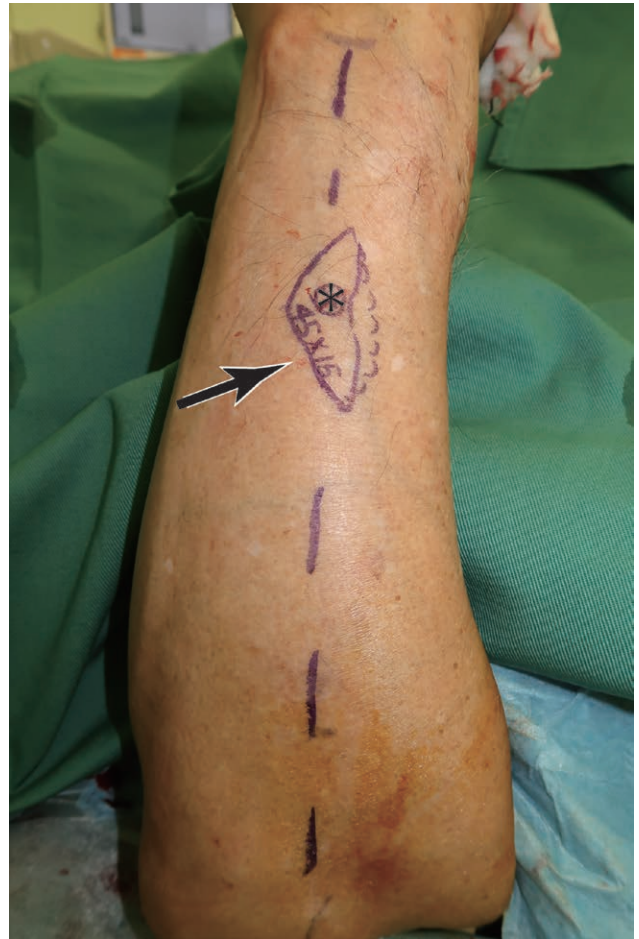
During surgery, the perforator of posterior interosseous artery was identified on a line connecting the lateral epicondyle of the humerus to the distal radioulnar joint by ultrasonography and a handheld Doppler device, as marked by an asterisk (*). A free PIAP flap was designed to include the perforator and the surrounding adipose tissue, as shown by the black arrow.
